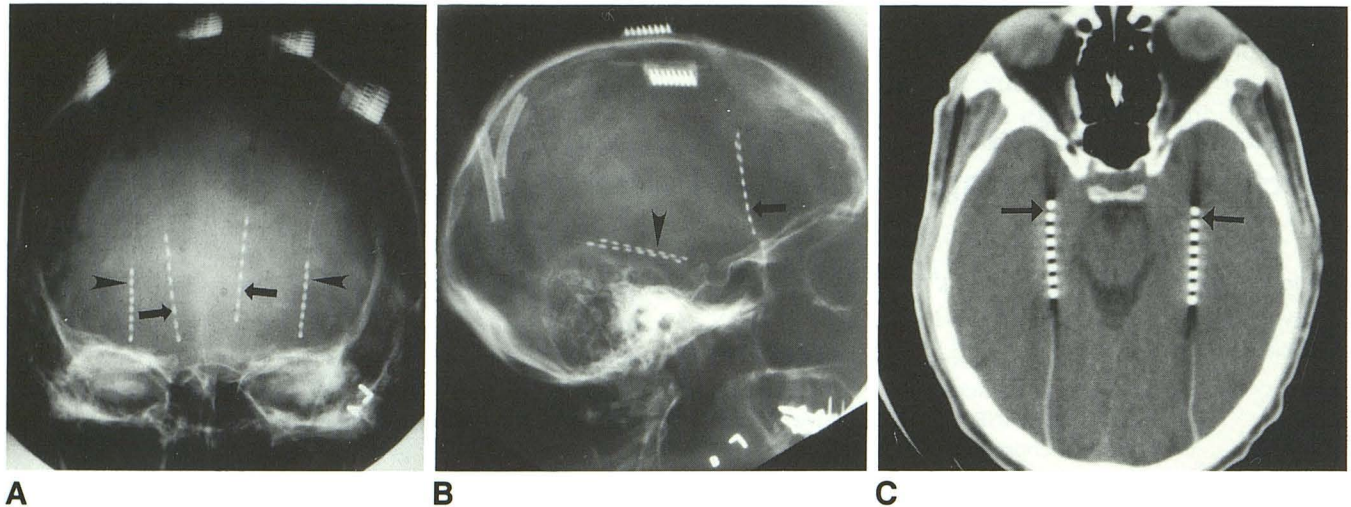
Typical placement of depth electrodes. A and B, anteroposterior and lateral views of the skull, demonstrating typical location of the frontal (*arrows*) and temporal (*arrowheads*) lobe depth electrodes. C, Axial CT demonstrating location of temporal lobe electrodes. The electrode tips (contacts 1-2) (*arrows*) are placed in the amygdala with the rest of the electrode extending posteriorly through the hippocampus.
